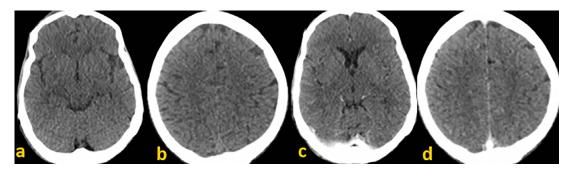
Axial computed tomography (CT) without (a, b) and with (c, d) contrast agent injection: no abnormal signal.
